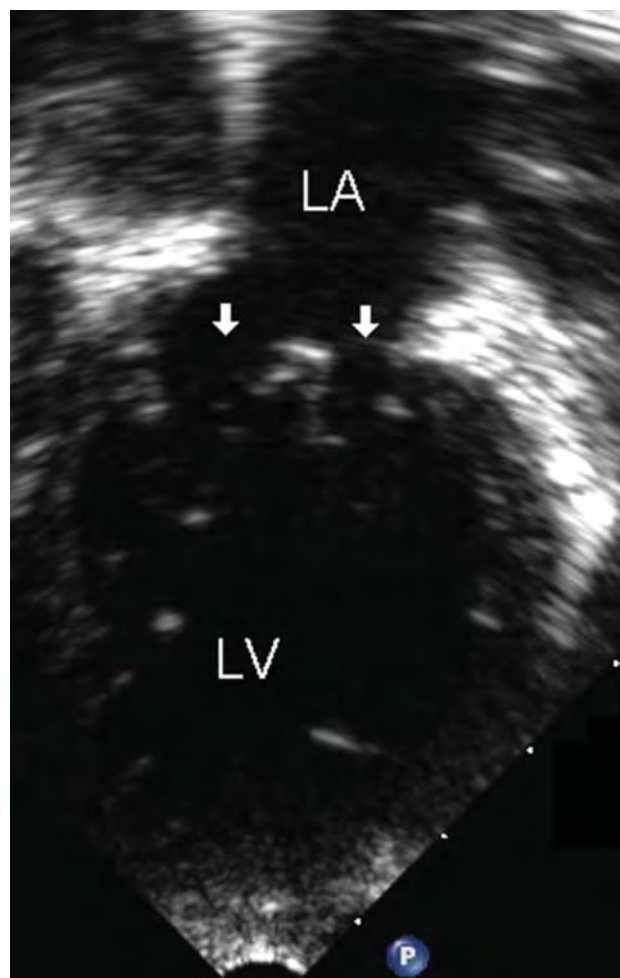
Apical four-chamber view showing a double orifice MV with the two orifices marked by white arrows. LA, left atrium; LV, left ventricle.
